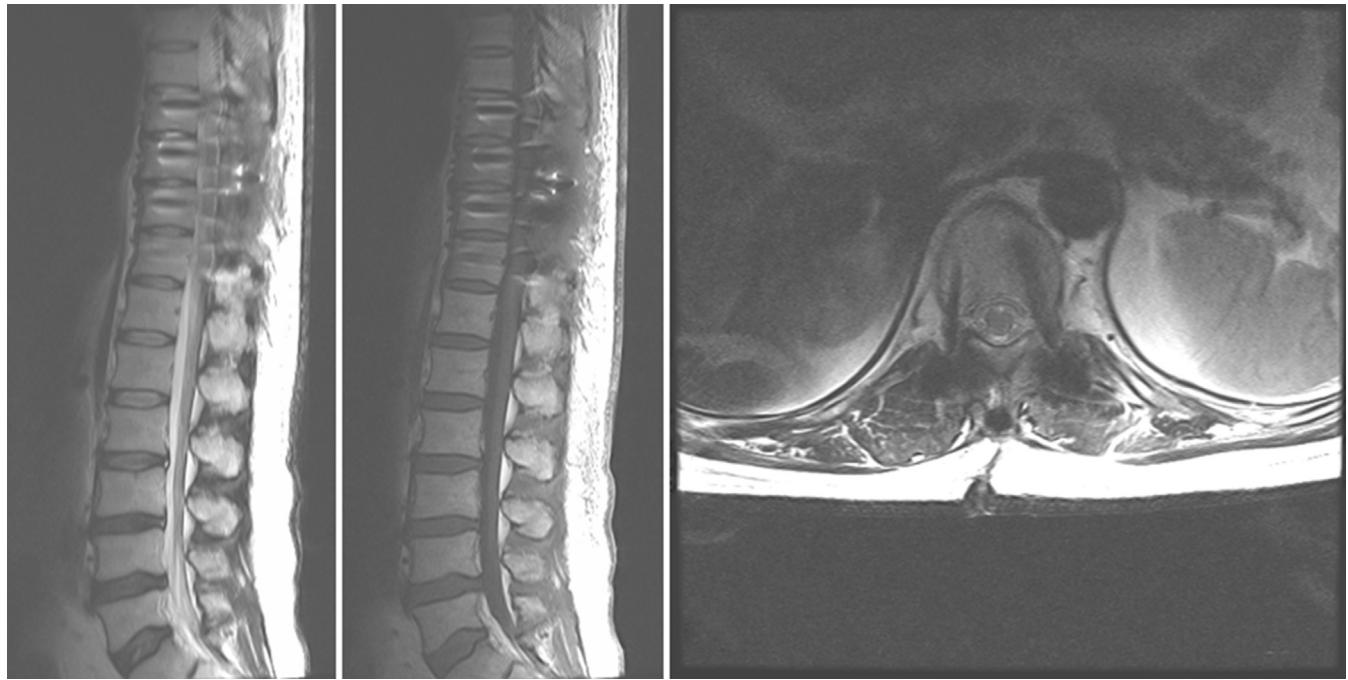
(Left, Middle, Right) Sagittal and axial magnetic resonance images showed no abnormality in other vertebrae after surgical management, chemotherapy, and bone marrow transplantation.
